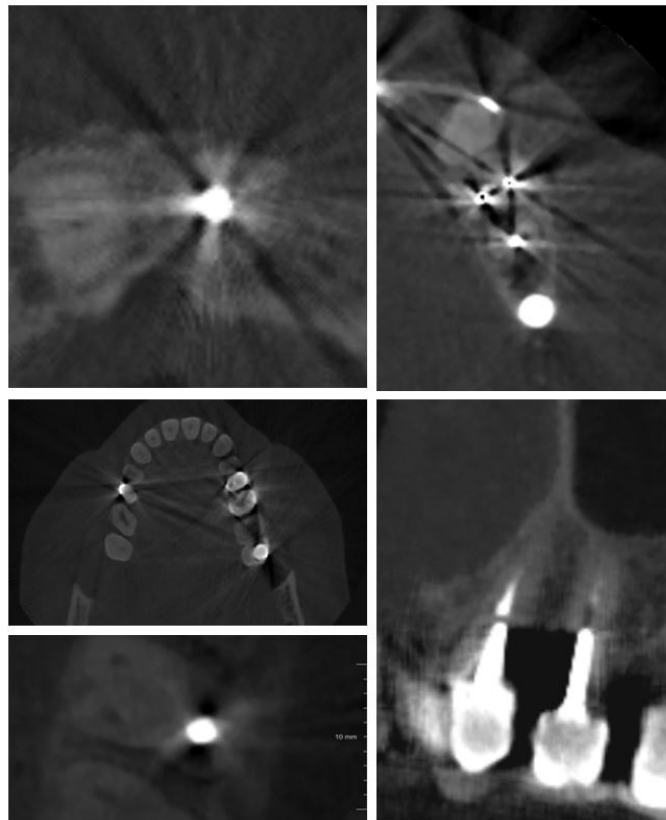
Examples of the effect of metal artifacts on CBCT images
